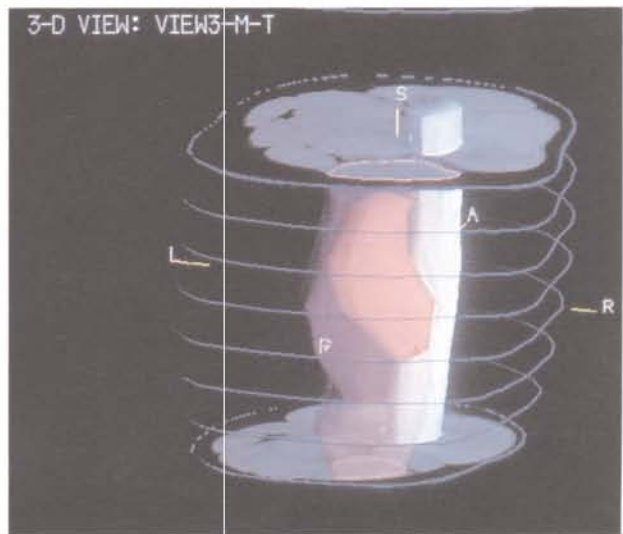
d. Volumetric image constructed from the outlines in the 8 CT sections described in Fig. II.5.c. The most proximal and distal sections are shown with a gray scale. The femur is displayed as a solid structure (white) as well as the gross tumor (pink), while the biceps muscle is displayed as a semitransparent structure (magenta). The spatial relationship of these structures can easily be conceived. The orientation of the image is given by the patient related coordinate system (L = Left, R = Right, S = Superior, I = Inferior, A = Anterior, P = Posterior).
